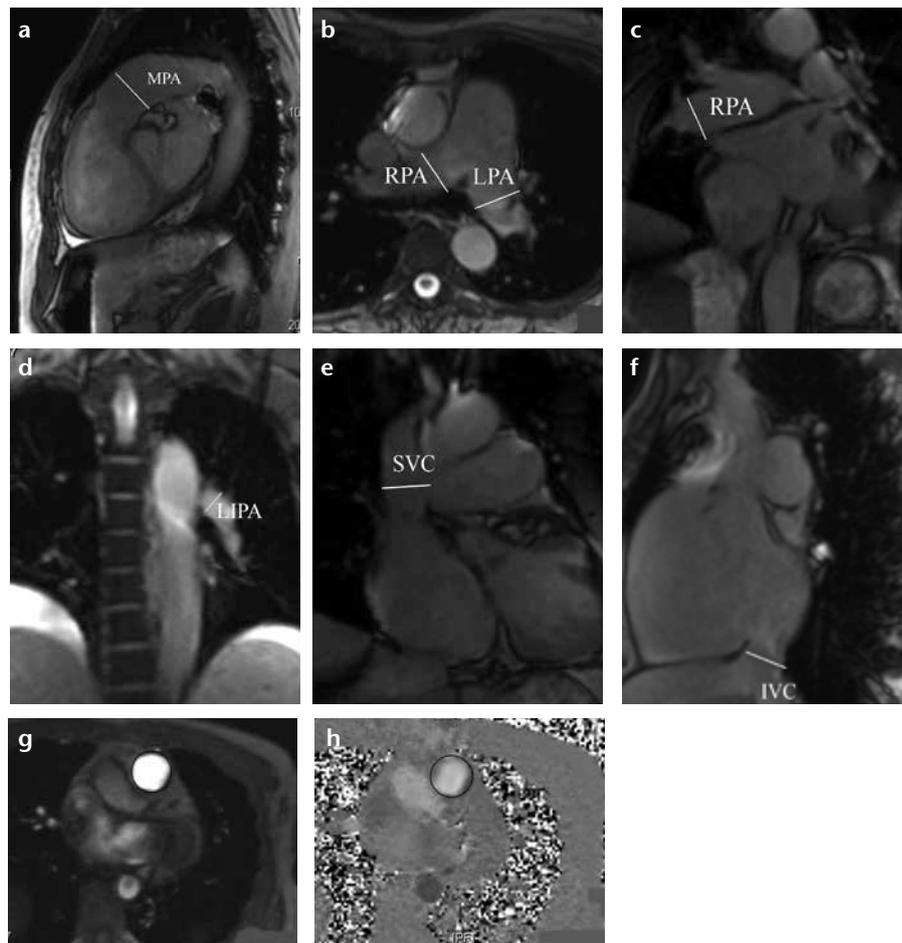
a–h. Imaging plane of phase-contrast MRI for flow measurement of each pulmonary artery and vena cava in patients with CTEPH (a–f). Phase-contrast MRI of main pulmonary artery (MPA, outlined in white) showing both anatomy (g) and flow velocity (h). MPA, main pulmonary artery; RPA, right pulmonary artery; LPA, left pulmonary artery; LIPA, left interlobar pulmonary artery; SVC, superior vena cava; IVC, inferior vena cava.
